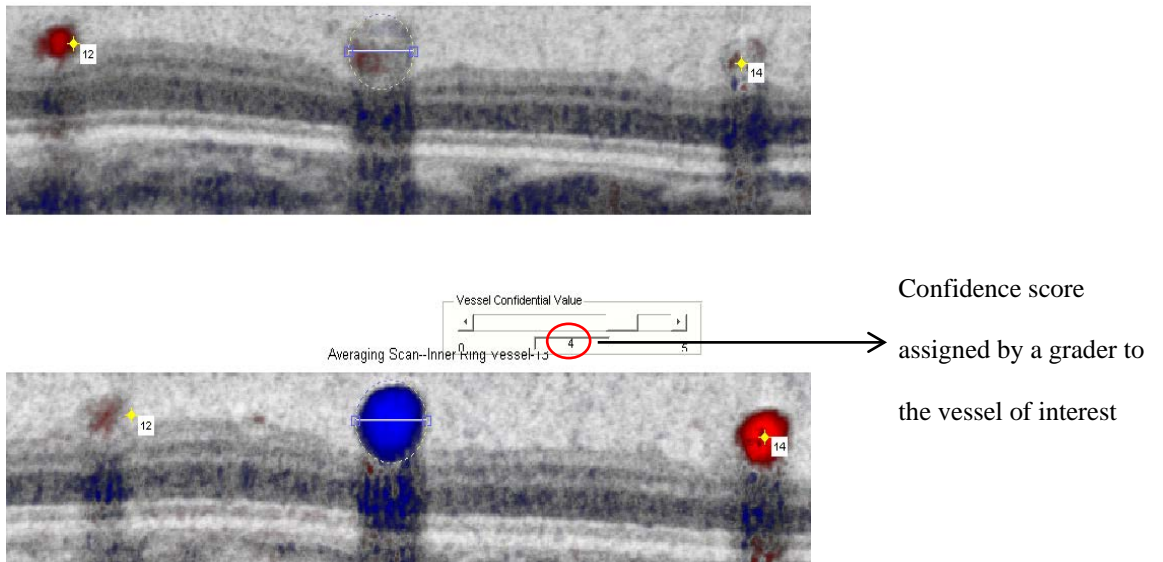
Cross-sectional image of blood vessel showing Doppler signal. Grader adjusts the vessel circumference using dotted circle and diameter using horizontal solid line.
